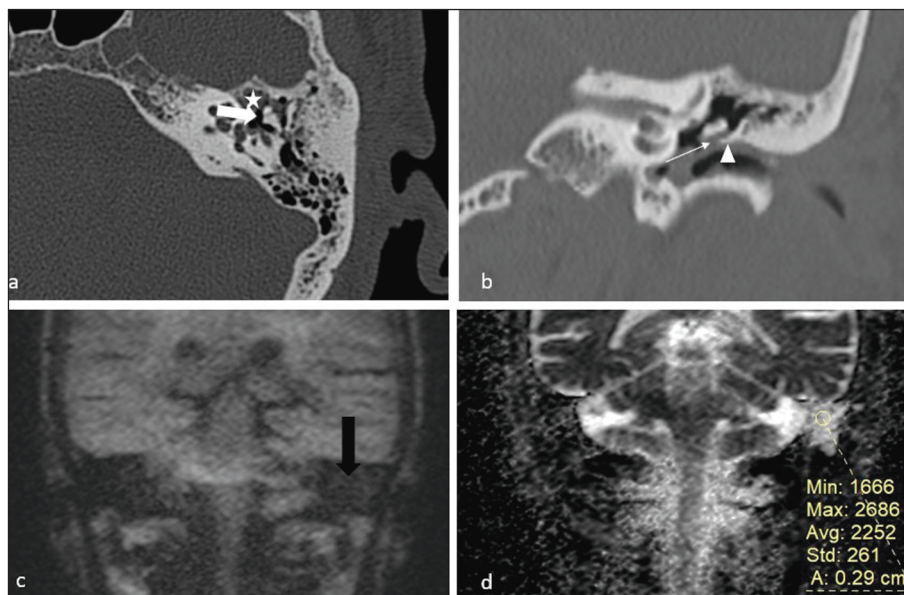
Temporal bone high-resolution computed tomography images in axial (a) and coronal planes (b) of a 65-year-old male patient without blunting of scutum (arrow head) and destruction of ossicles (thick white arrow). In non-echo-planar imaging diffusion-weighted images (c) and the corresponding apparent diffusion coefficient map (d) of the same patient, there is no diffusion restriction.
